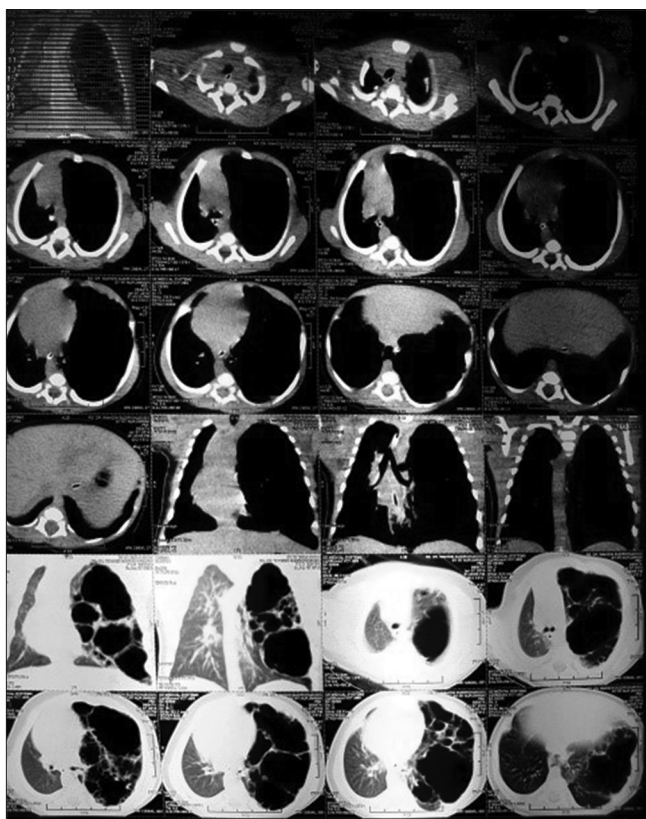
The non-contrast CT chest showed multiple cyst lesions at the left hemithorax and shifting mediastinum to the right side
